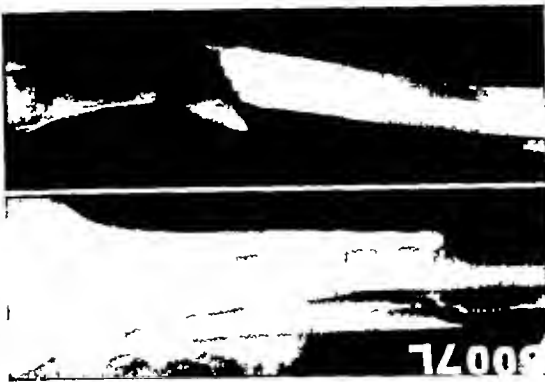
Roentgenograms of a compound fracture of a tibia before and after débridement and reduction with internal fixation. Vitallium plate and screws used. Note length of plate and selection of screws so that each screw transverses both cortices of the tibia.
